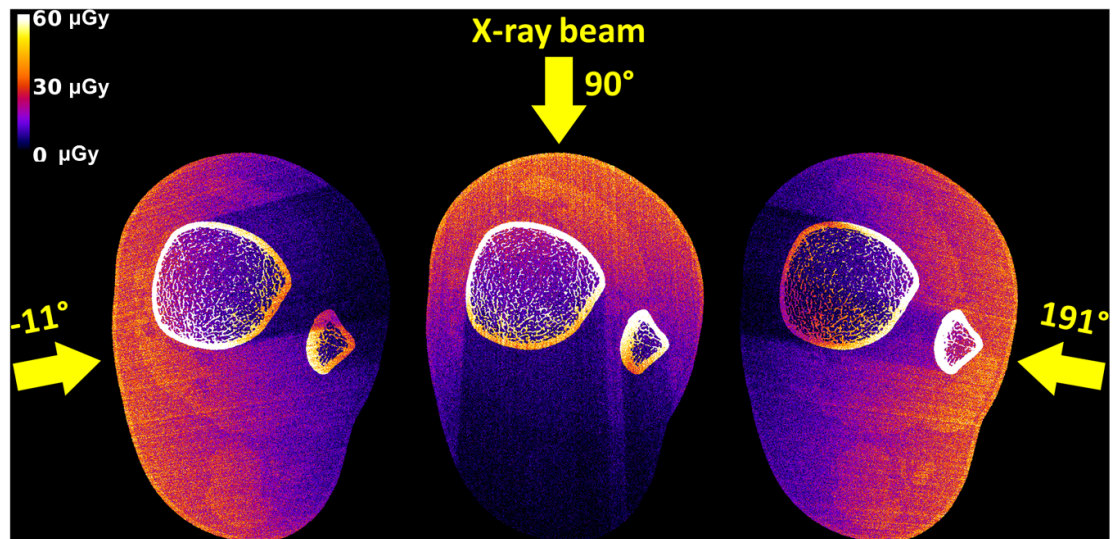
Absorbed dose maps in the central slice of the tibia for three single projections (angular position of the source -11° , 90° , or 191°). By summing the 3D dose maps for the 1011 projections, one obtains the absorbed dose maps for the whole CT scan (figure 6). Note that the scale is in μGy units, as these dose maps are obtained from single projections.
